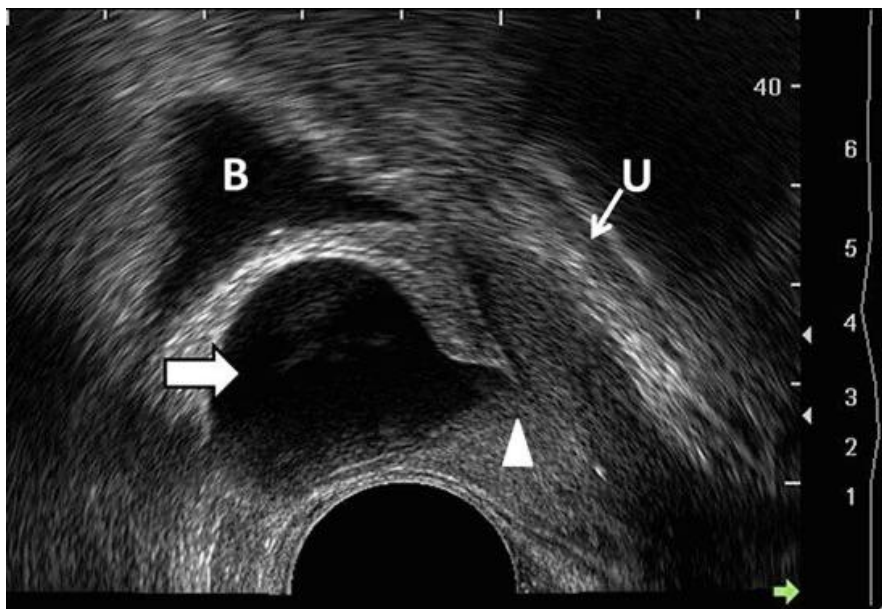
Transrectal sagittal sonogram of the prostate demonstrating utricular cyst. The image shows a well-defined pear-shaped anechoic lesion in the midline consistent with utricular cyst (arrow). B bladder, ureter (U) (1)
